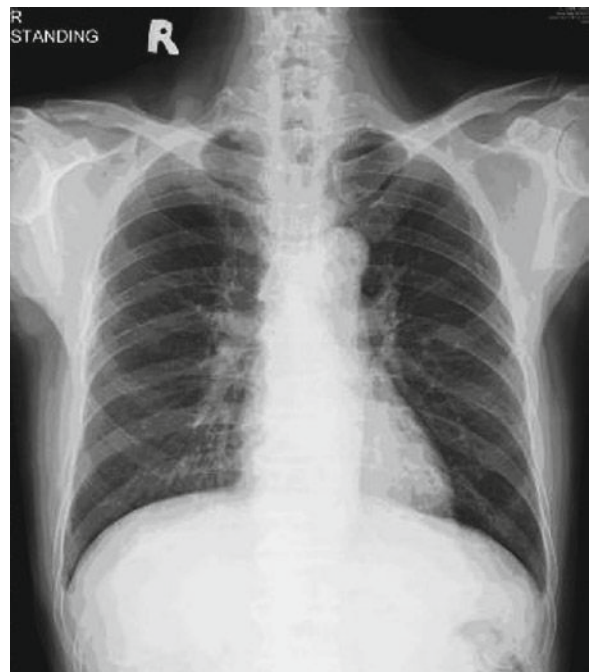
A chest radiograph showed unremarkable findings. No lung infiltrates, nodules, or tumors were visible
